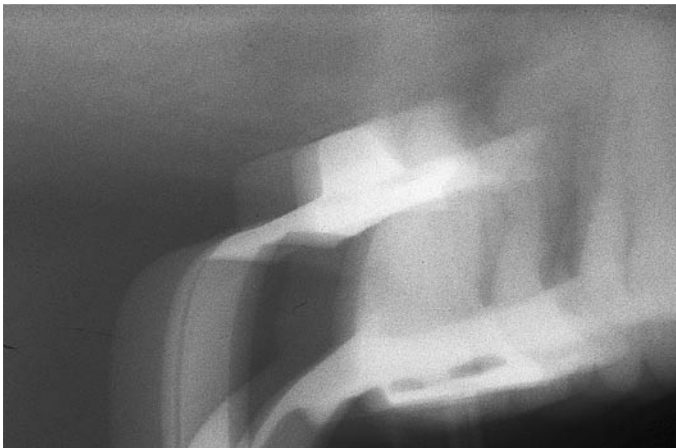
Blurred radiograph caused by movement during exposure.
